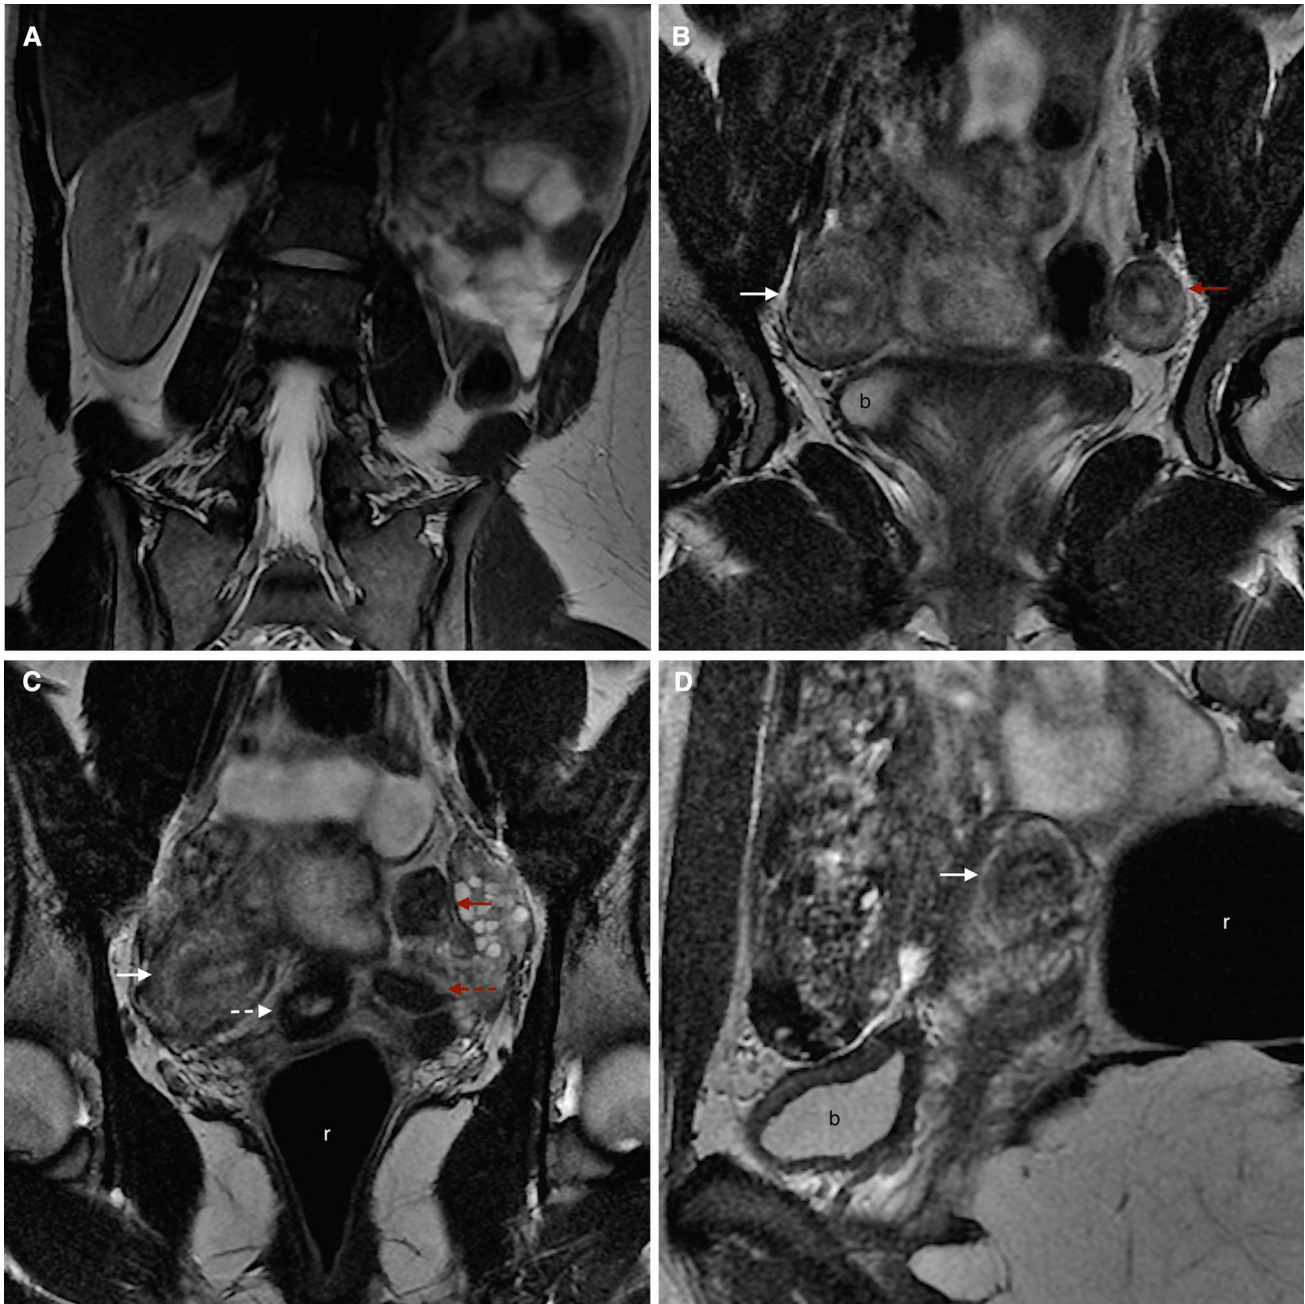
A–F Images in a 17-year-old girl who complained with a 6-year history of severe dysmenorrhea (A–C coronal T2WI; D, E sagittal T2WI; F axial T2WI). MRI showed a left renal agenesis (A) and a uterus didelphys. Two independent uterine horns and two non-communicating cervixes are recognized. The right uterine horn (B–D white arrow) and cervix (C–E white dashed arrow) have a normal appearance. The left uterine horn is smaller (B, C red arrow), and the ipsilateral
